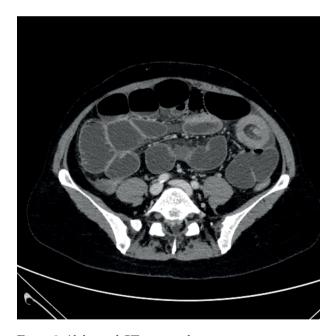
Abdominal CT scan: axial view
